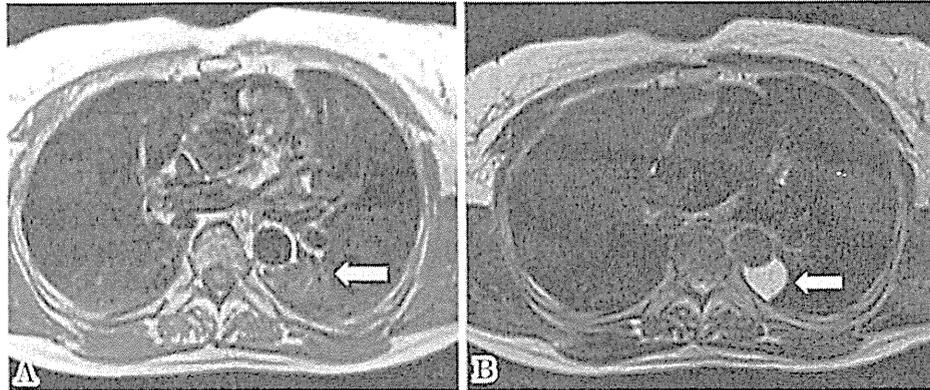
Chest MRI showing the cystic mass consisting of a thin wall and homogeneous content with a low signal intensity on T1-weighted imaging (A) and a high signal intensity on T2-weighted imaging (B) (arrow).
